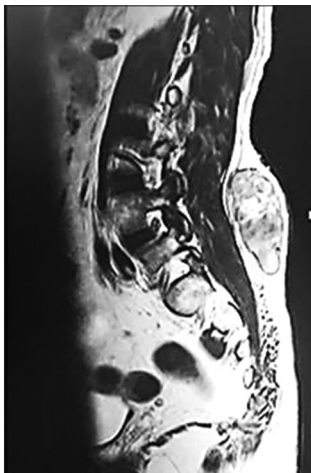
Lumbar MRI shows solid mass on L4–L5
